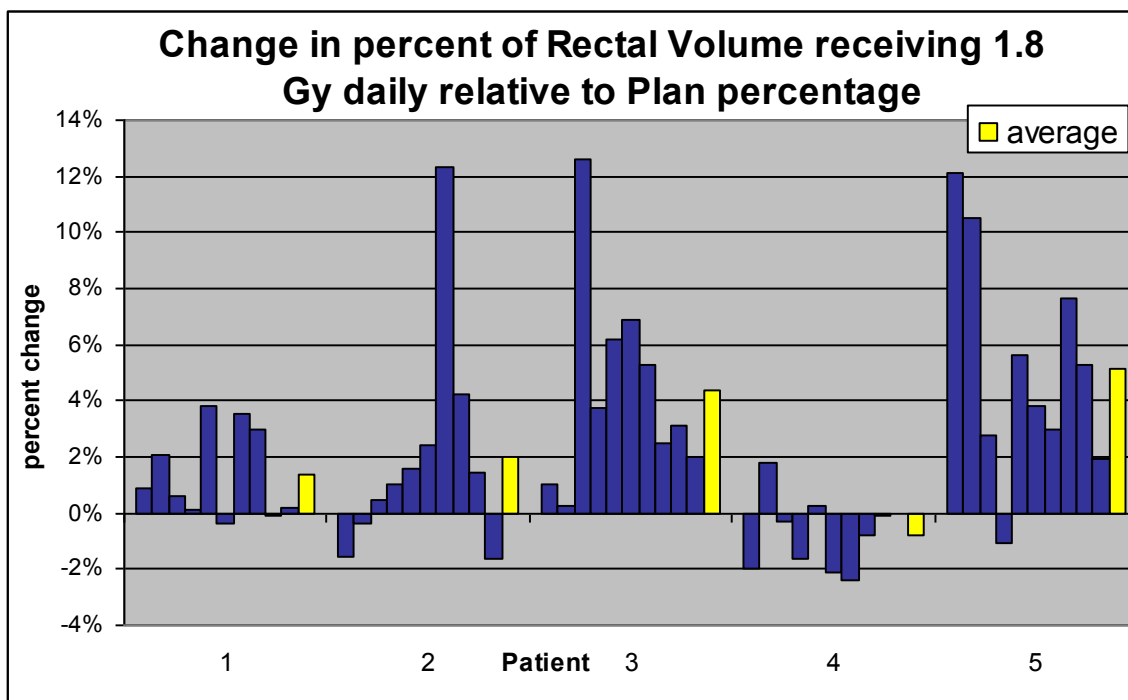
Change in percentage of rectal volume receiving 1.8 Gy relative to the treatment plan value listed by patient. Positive values indicate an increase in the volume of the rectum receiving 1.8 Gy; negative values indicate a decrease in rectal volume at that dose. Each column represents data from one selected daily cone-beam scan per consecutive week of treatment. The average over these values for the course of treatment is shown by the yellow bars.
